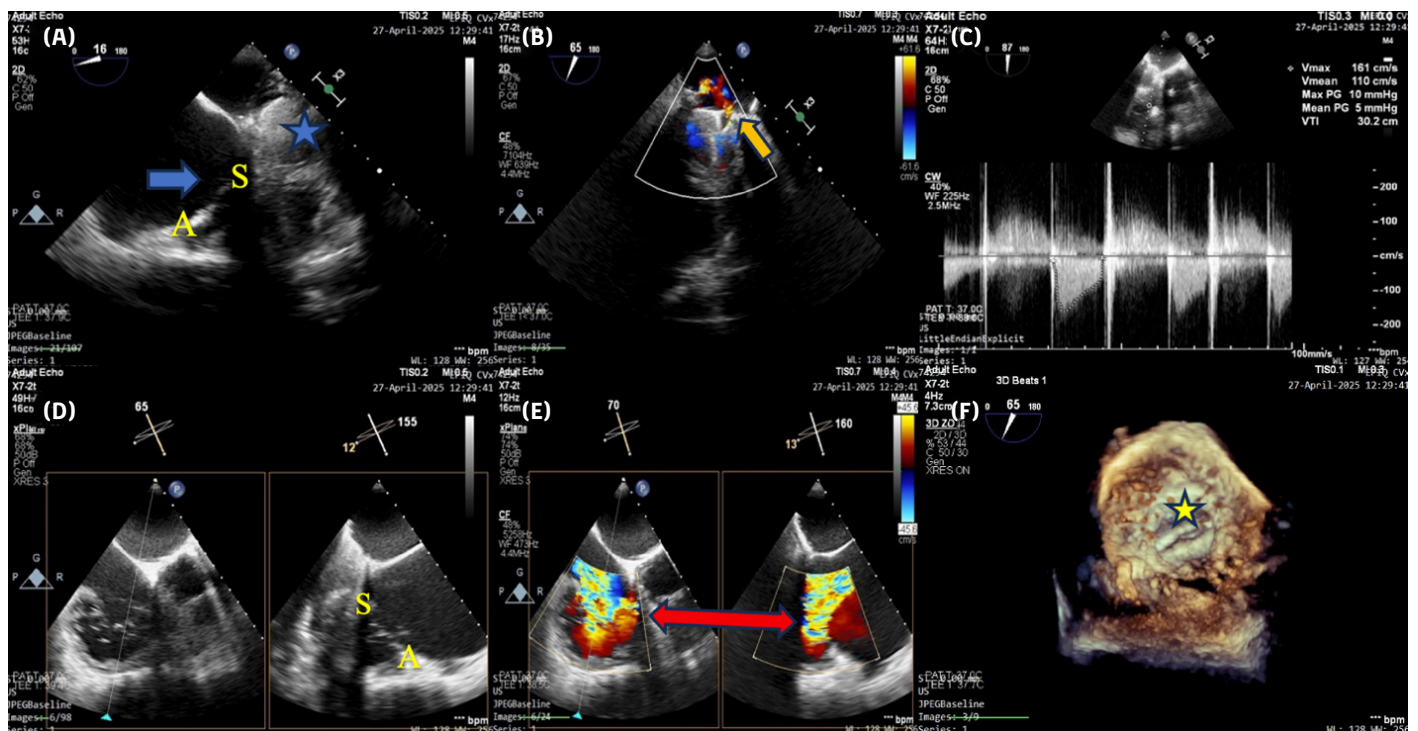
Pre-procedural transesophageal echocardiographic (TEE) images: (A) Mid-esophageal four-chamber view at 16° showing the mechanical mitral valve replacement (MVR) (blue star) and tricuspid valve leaflets (blue arrow; A: anterior leaflet, S: septal leaflet); (B) Mild paravalvular leak observed on MVR assessment (orange arrow); (C) MVR gradient measurement with a maximum/mean peak gradient of 10/5 mmHg; (D) X-plane view in the mid-esophageal right ventricular inflow-outflow window showing anterior (A), posterior, and septal (S) leaflets of the tricuspid valve; (E) Color Doppler imaging in the right ventricular inflow-outflow view demonstrating torrential tricuspid regurgitation (double-headed red arrow), with a vena contracta (VC) ≥ 21 mm; (F) 3D TEE view of the MVR (yellow star).
